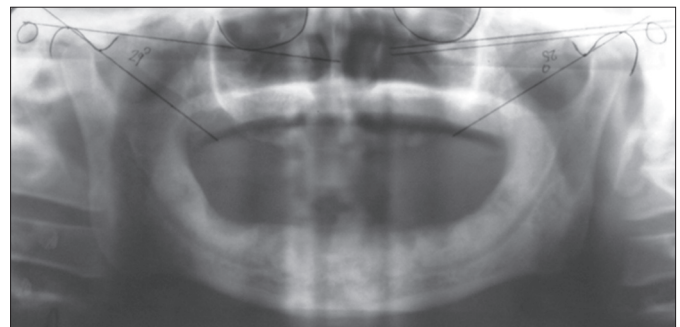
Tracing of condylar guidance angle on panoramic radiograph in edentulous patients.
